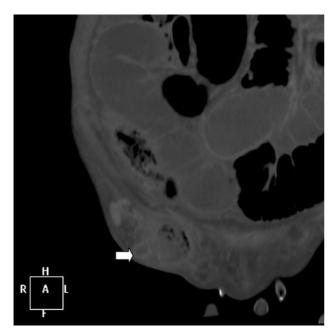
Coronal CT image of femoral hernia with *arrow* identifying appendix
